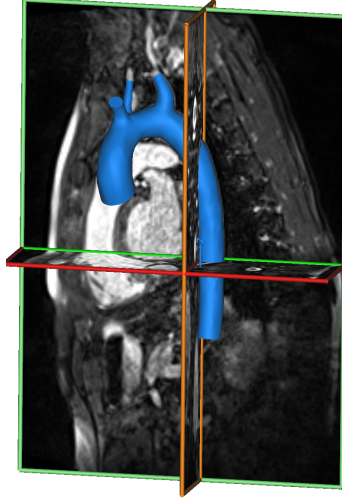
3D model of the aortic arch extracted from MRI images.
